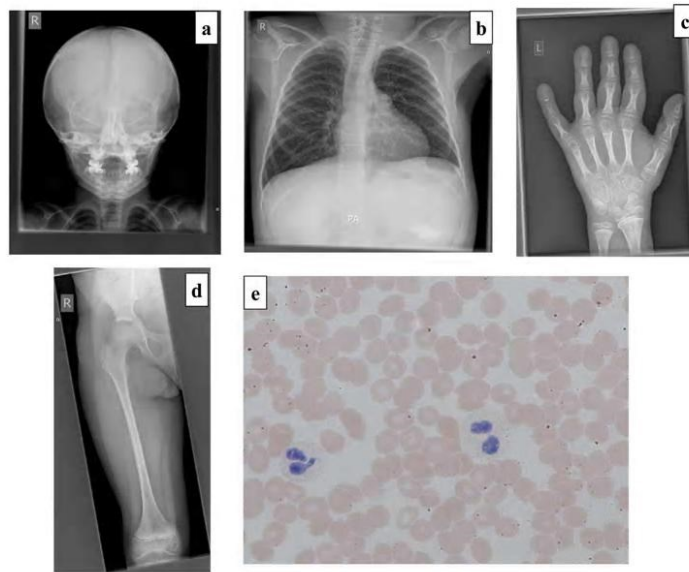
Radiographs demonstrating slender ribs, tubular long bones with thin cortices and osteopenia consistent with a diagnosis of OI. 2a: AP skull radiograph (aged 6 years). There are multiple Wormian bones; the clavicles are slender and the erupted teeth are relatively dense. The anterior fontanelle remains open. 2b–d: Selected images from a full dysplasia skeletal survey (aged 9 years 8 months). 2b: Left hand. There is significant periarticular osteopenia (see panel c). The metacarpals (and less marked) the proximal phalanges are overmodelled and there is an ivory epiphysis of the terminal phalanx of the fifth finger. The terminal tufts are prominent. 2c: AP chest. The ribs and clavicles are slender; however, there are no fractures and vertebral body height is preserved. Note the presence of a gastrostomy. 2d: AP right femur. Overmodelled with slender diaphysis and relatively flared distal metaphysis. Periarticular osteopenia is again noted (see panel a). 2e: Peripheral blood film in Patient 1 demonstrating a hypolobulated neutrophil (left) and a Pelger-Huet cell (right).
